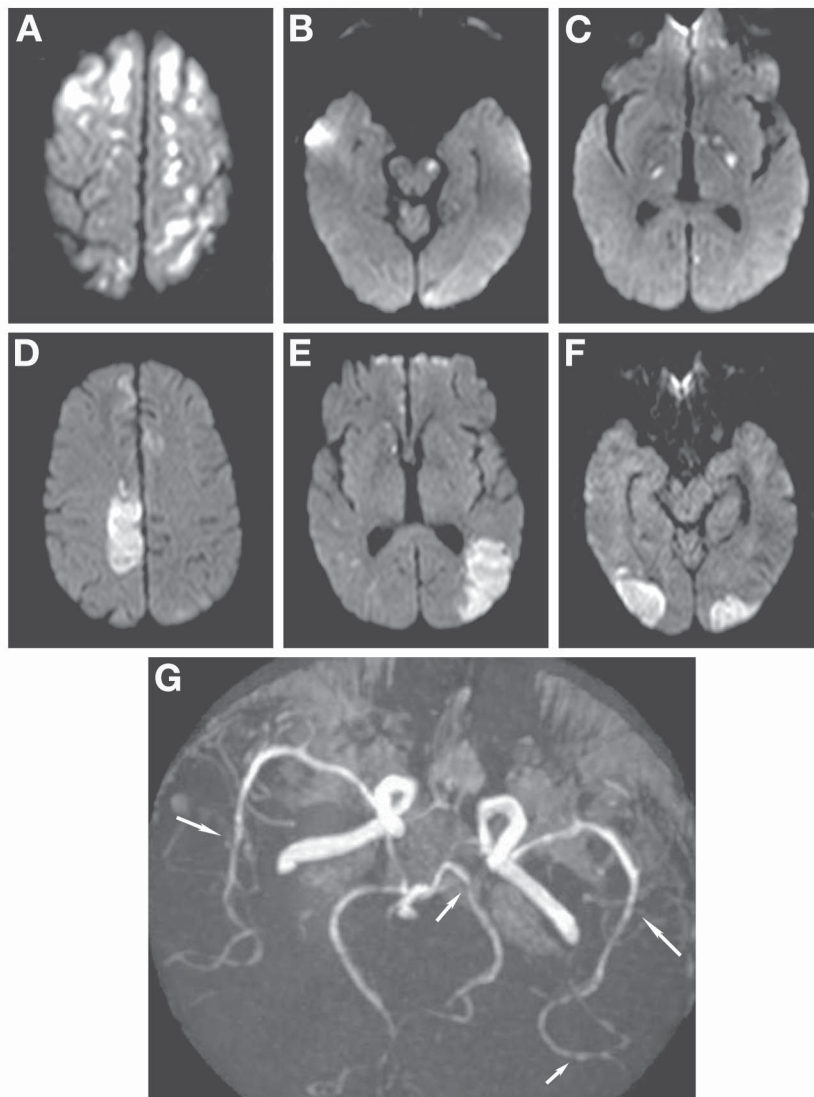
Axial diffusion-weighted MRI shows multiple lesions in the superior part of the frontal and parietal lobes (A) in the midbrain (B) and in the basal ganglion areas (C). After reduction of prednisone, repeated MRI revealed new right fronto-parasagittal lesions (D), left temporo-occipital (E), and occipital areas (F). Angio-MRI revealed vessel-wall irregularities (arrows), focal dilatation, and narrowing, mostly in the middle and posterior cerebral arteries (G).
